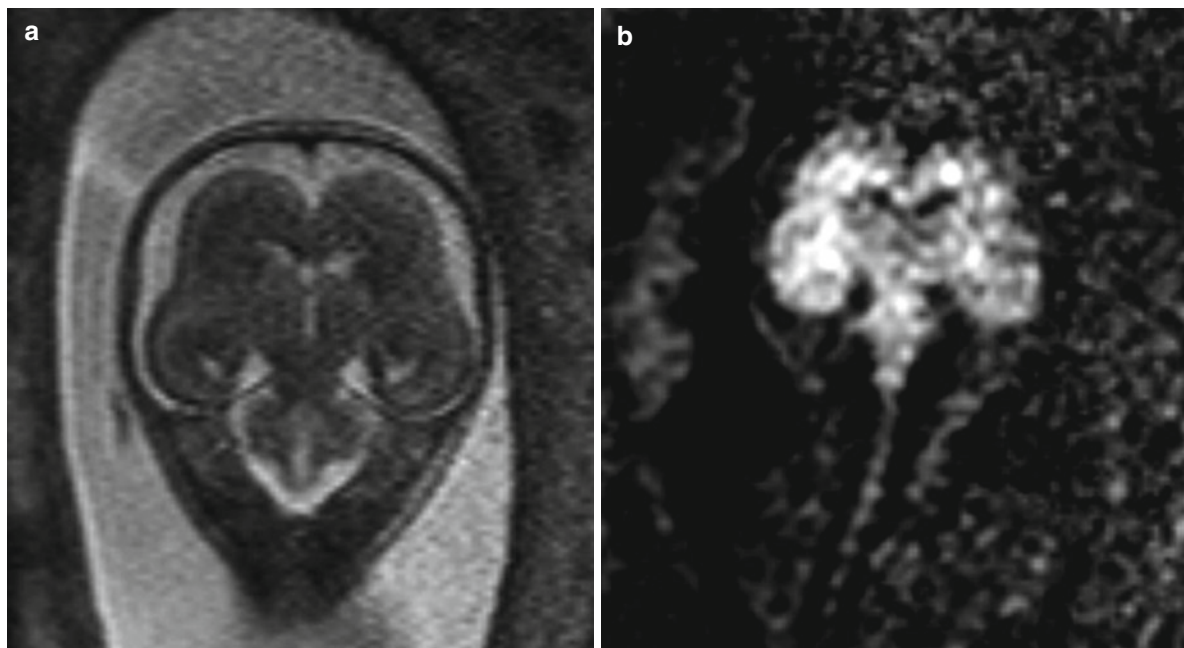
Coronal T2-weighted images (a) and diffusion-weighted images (b) showing the disturbed lamination and too shallow insula indentation indicating the presence of lissencephaly I at GW 24+3
